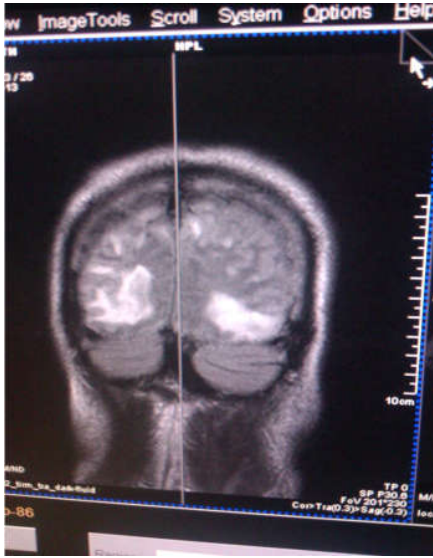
MRI Brain T2 FLAIR coronal showing bilateral parieto-occipital hyperintensities in a case of PRES
